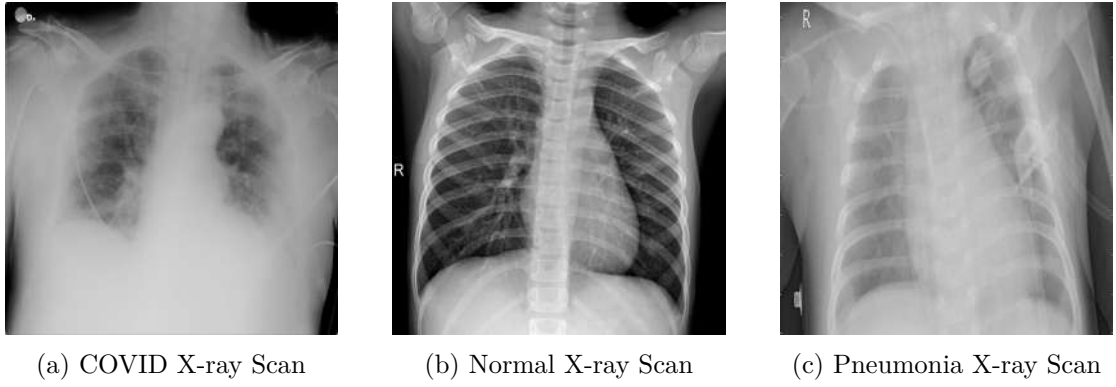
X-ray Scans of COVID Radiography Dataset
